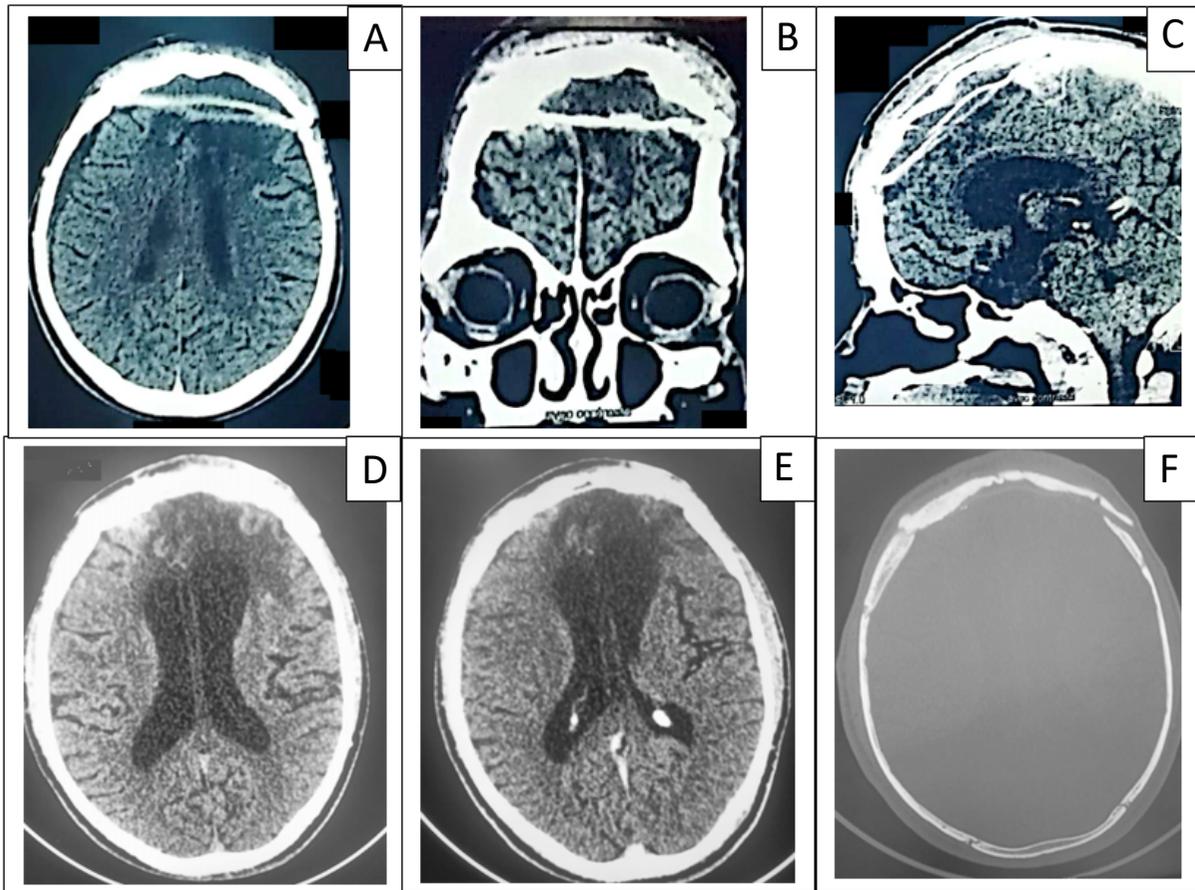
4-month (A, B, C) and 16 months (D, E, F) postoperative CT scan, CT at 4 months postoperative injected in axial section (J), coronal (K) and sagittal (L) reconstruction showing an absence of tumor residue, CT scan at 16 months postoperative in axial section without (D) and with contrast (E), in bone window (F) showing an absence of tumor recurrence and the bone plasty well in place
